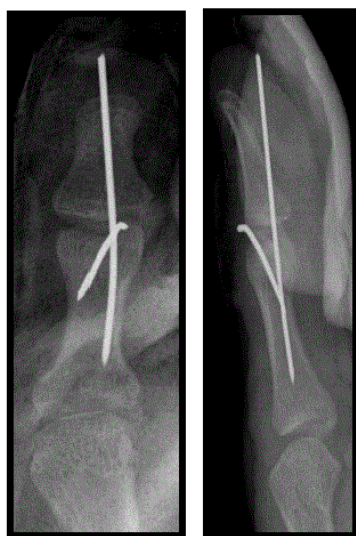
Post operative x-ray shows the antero-posterior and lateral view.
